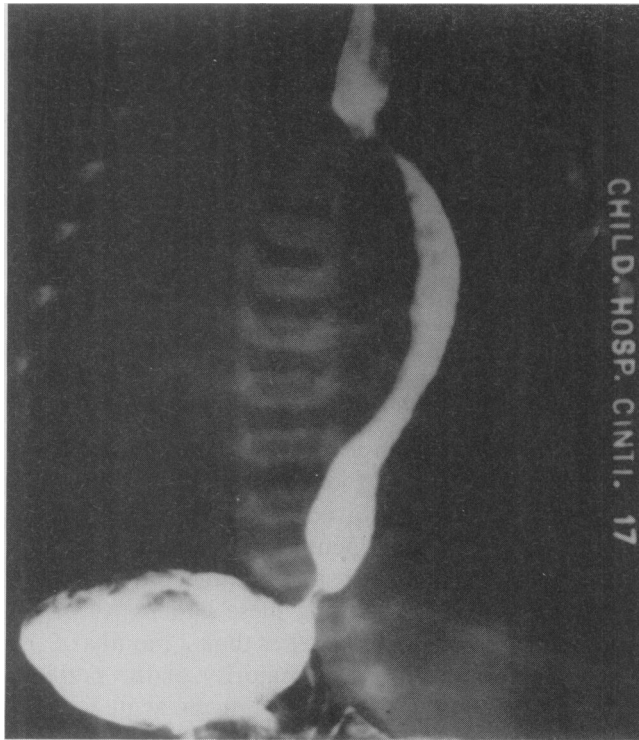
Radiograph of an esophageal duplication, demonstrating displacement of the esophagus by the duplication.
